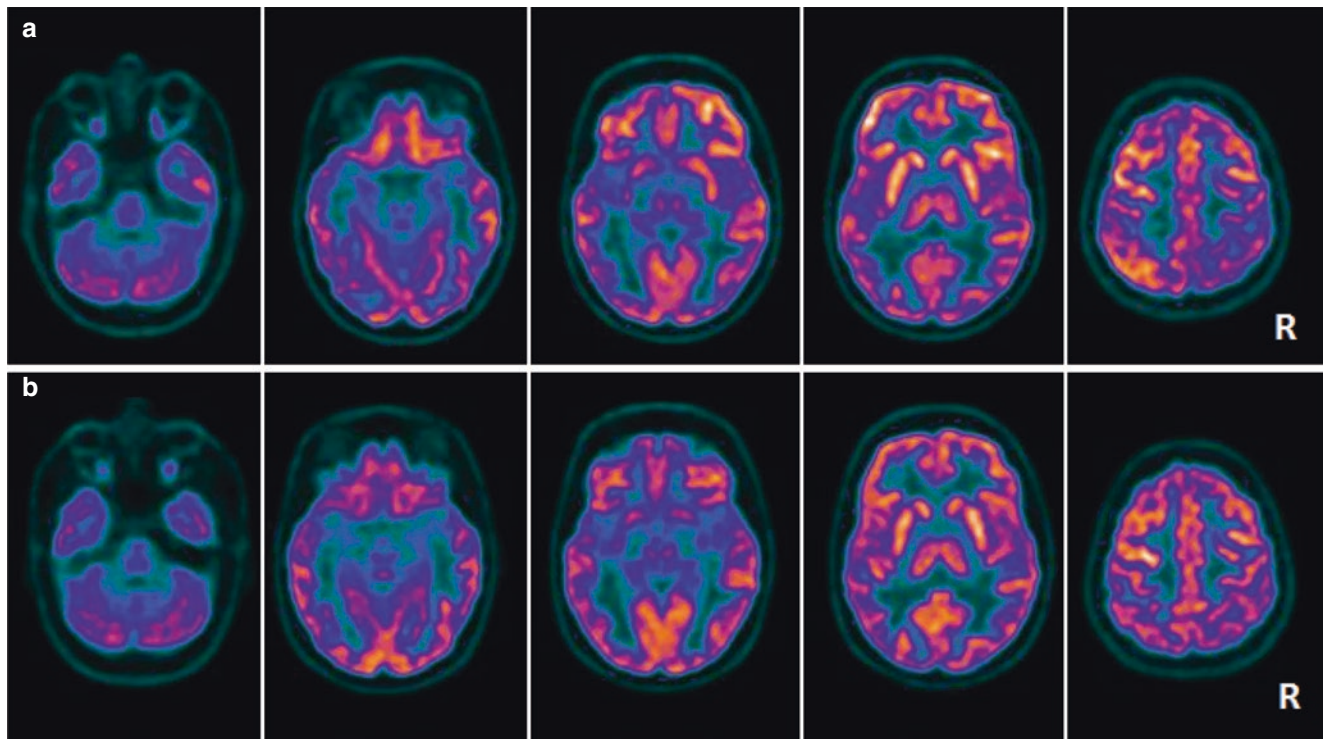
(a) 18F-FDG brain PET showing hypometabolism in the left temporal lobe, insula, and ipsilateral temporo-occipital junction and in the right superior parietal lobule. (b) 18F-FDG brain PET documenting a normalization of brain glucose metabolism 3 months after the treatment with plasmapheresis. (Reprinted with permission from Pari et al. [45])
